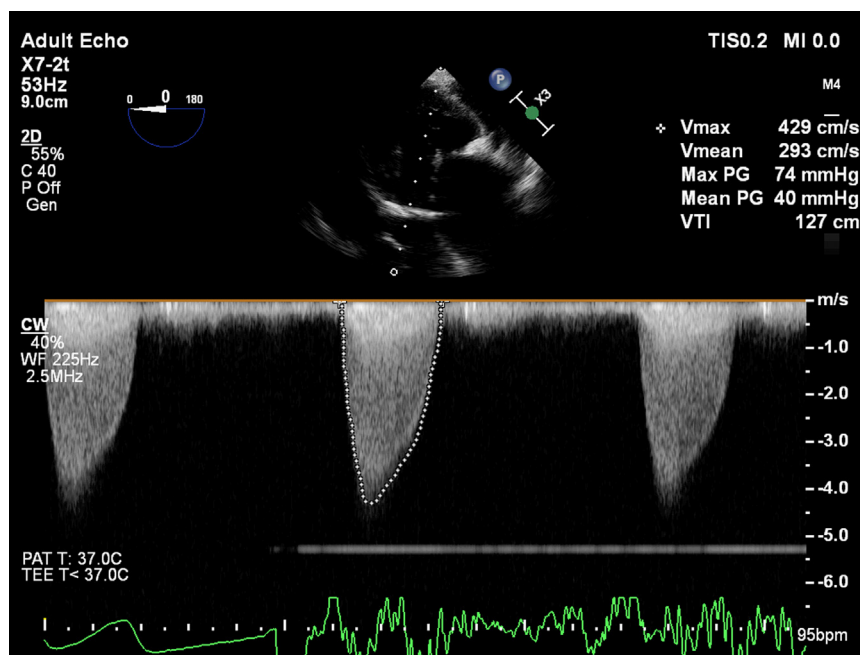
2D TEE deep transgastric view continuous wave Doppler indicating severe aortic stenosis.
